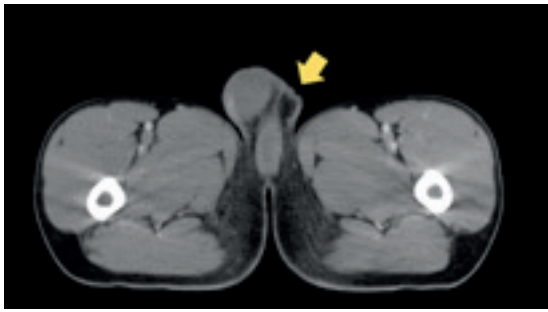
The left testis, which is not in its normal position on the CT scan (arrow head)
